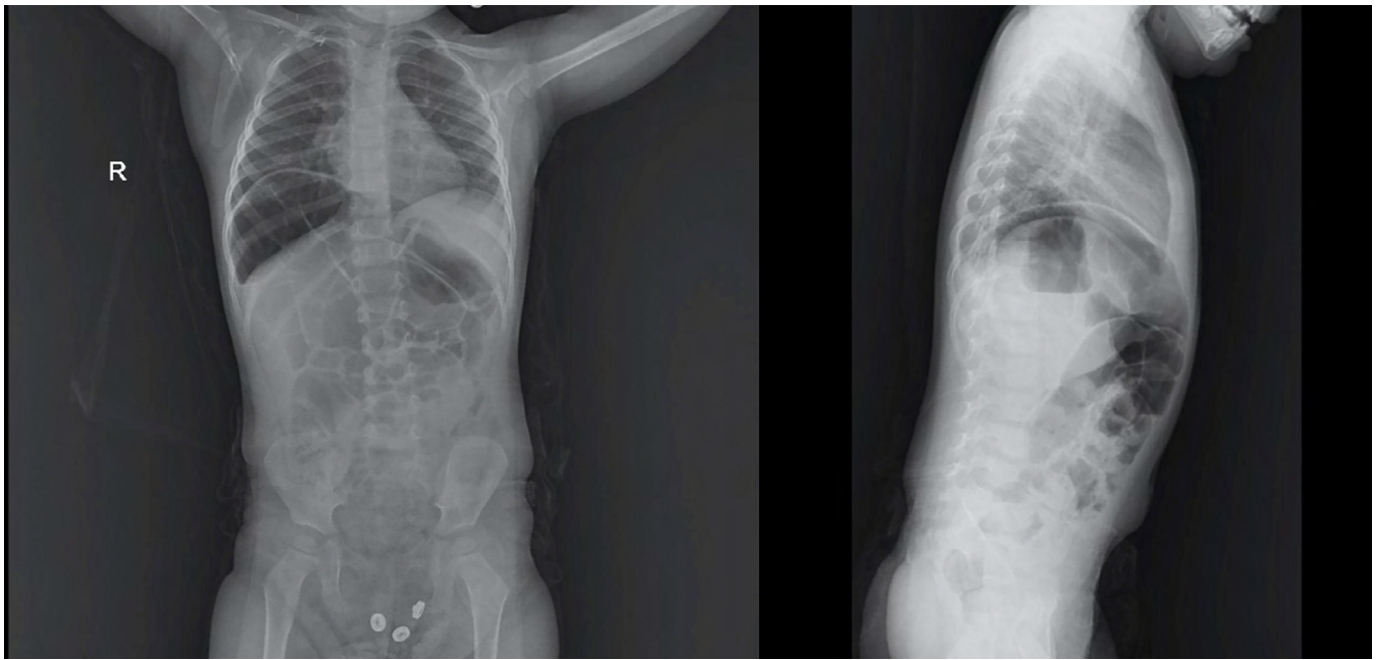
Anteroposterior and lateral chest radiographs showing interposed colonic loops between the diaphragm and liver, consistent with Chilaiditi syndrome. This radiological appearance may mimic pneumoperitoneum and should be carefully differentiated.
